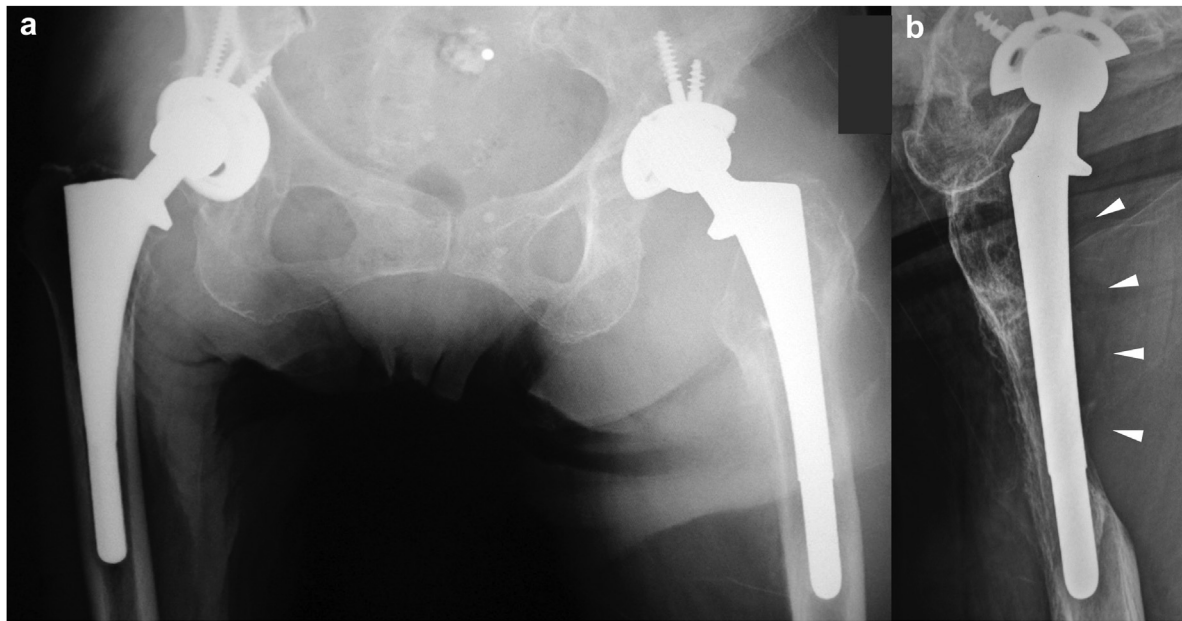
Plain radiograph of the left hip.
